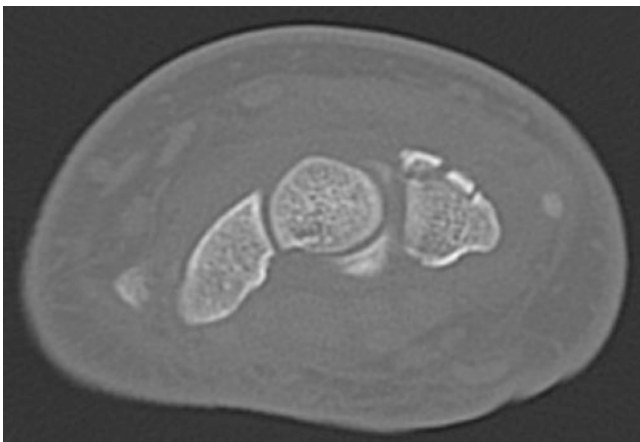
CT scan demonstrating a dorsal 'chip' avulsion fracture of the triquetrum
